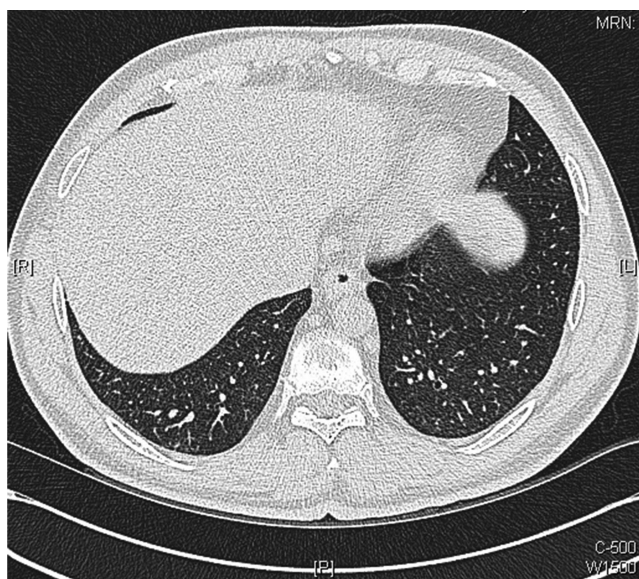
Axial images of repeat chest CT scans performed 10 weeks after initiation of antituberculosis medications: showing further improvement with resolution of many of the smaller intrapulmonary nodules.
